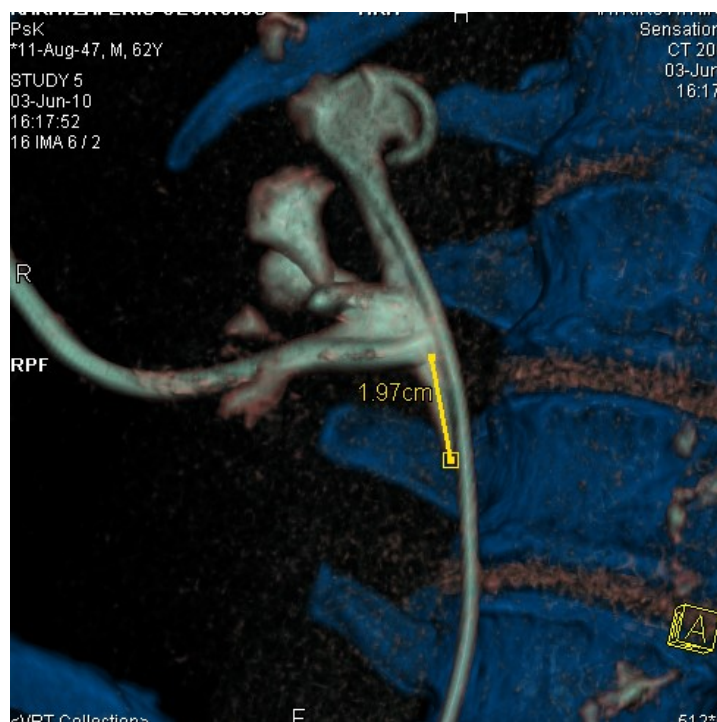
CT Urography 2010.
